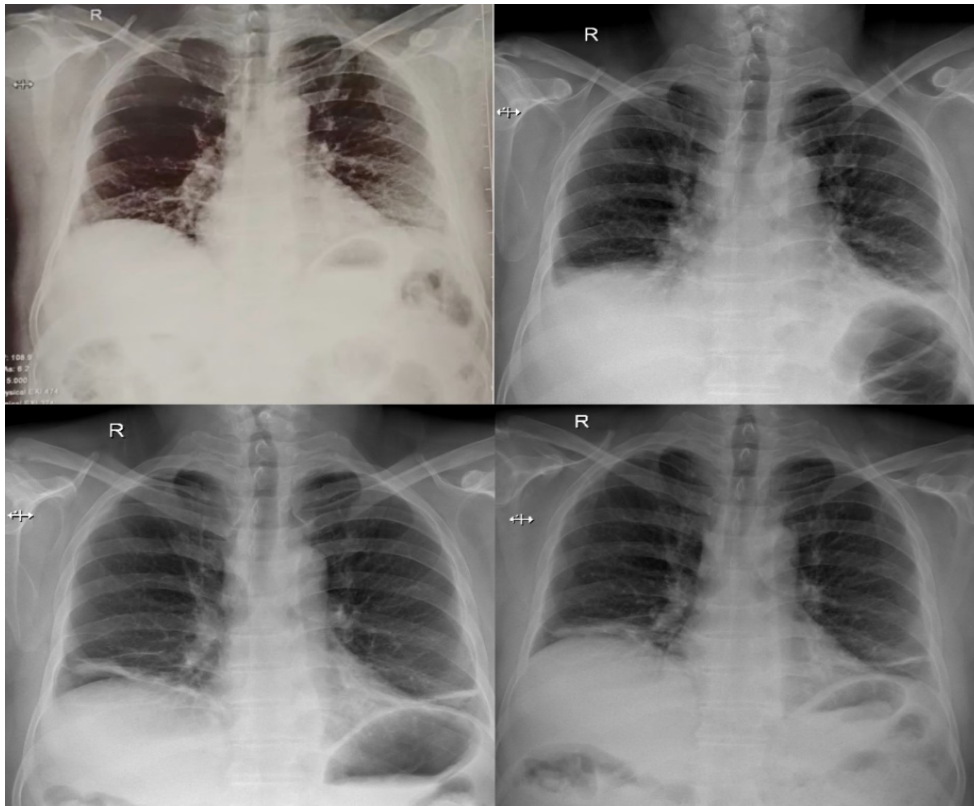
Chest x-ray showed inhomogeneous opacity with fiberoptic band in bilateral lower lobes with left Costophrenic angle blunting. Last x-ray shows resolution
